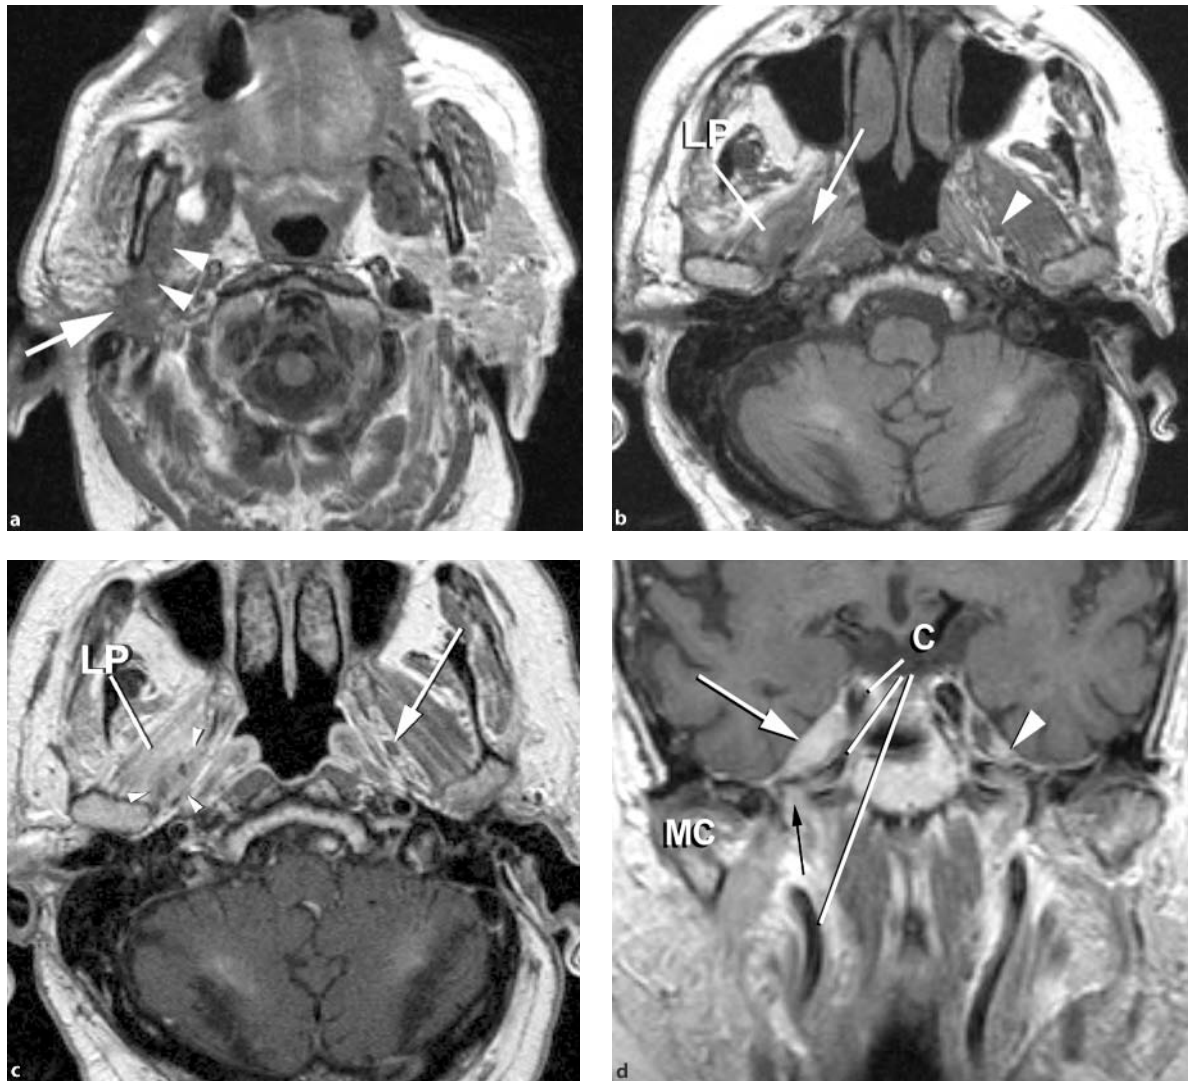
Carcinoma of the parotid gland with perineural spread along the auriculotemporal nerve of the trigeminal nerve through the foramen ovale to the gasserian ganglion and Meckel's cave, MRI. a Axial T1-weighted image without contrast shows the infiltrative tumor in the parotid gland (arrow). There had been previous surgery. There is tumor (arrowheads) extending along the auriculotemporal nerve into the masticator space toward the main branches of the third division of the trigeminal nerve. b Axial T1-weighted image without contrast just inferior to foramen ovale. The tumor enlarges the nerve just beneath foramen ovale obliterating the important fat plane (arrow) along the medial margin of the lateral pterygoid muscle (LP). The lateral pterygoid muscle has atrophied slightly due to denervation. Note the normal trigeminal nerve third division (arrowhead) on the opposite side along the medial margin of a normal lateral pterygoid muscle. c Postcontrast T1-weighted image at the same level as b. Denervated lateral pterygoid (LP) muscle shows slight enhancement. The tumor (arrowheads) extending along the trigeminal nerve is better defined within the fat just inferior to foramen ovale. Note the appearance of the normal nerve (arrow) on the opposite side. d Coronal image through Meckel's cave. The tumor (white arrow) having followed the trigeminal nerve through foramen ovale obliterates the gasserian ganglion and the cerebrospinal fluid in Meckel's cave. Compare to the gasserian ganglion area (arrowhead) on the opposite side. Tumor just beneath foramen ovale (black arrow), mandibular condyle (MC), carotid artery (C)
